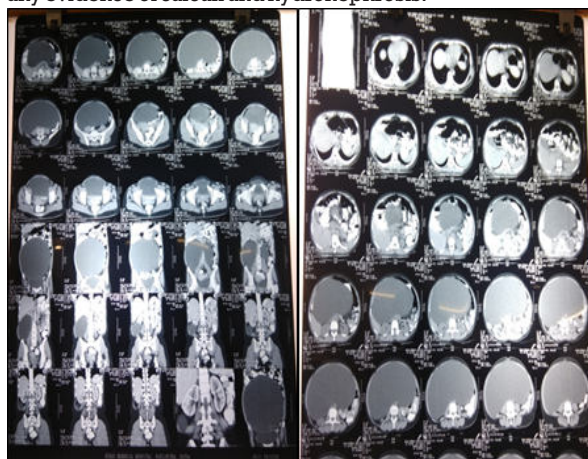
CT WHOLE ABDOMEN
